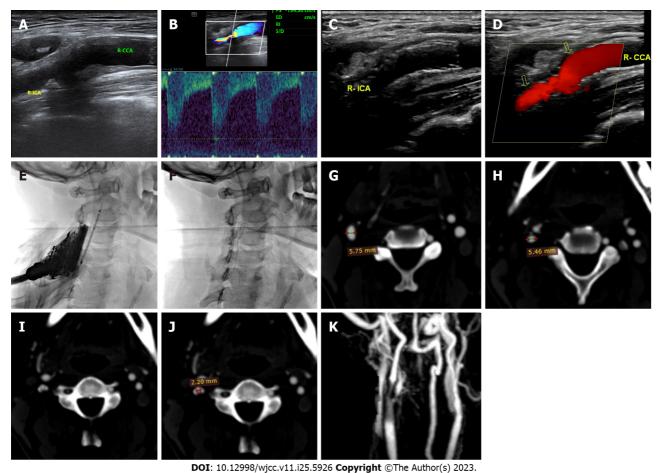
Images before and after carotid artery stent implantation. A: Ultrasound showing stenosis of the right internal carotid artery (R-ICA) before surgery; B: Ultrasound showing blood flow in the region of R-ICA stenosis before surgery; C: Ultrasound showing good stent shape of the R-ICA after surgery; D: Ultrasound showing good blood flow in the region of R-ICA stent after surgery; E: X-ray showing the shape of the stent before stenting; F: X-ray showing the shape of the stent after stenting; G: Preoperative computed tomography angiography (CTA) showing a proximal diameter at the site of R-ICA stenosis of 5.75 mm; H: Preoperative CTA showing a distal diameter at the site of R-ICA stenosis of 5.46 mm; I: CTA showing a cross-section of the site of R-ICA stenosis. The vascular lumen is in the middle, and calcified plaques are present at both ends; J: CTA indicating a lumen diameter at the site of R-ICA stenosis of 2.20 mm; K: Magnetic resonance angiography showing good stent shape after surgery. R-SCA: Right subclavian artery; R-ICA: Right internal carotid artery.
